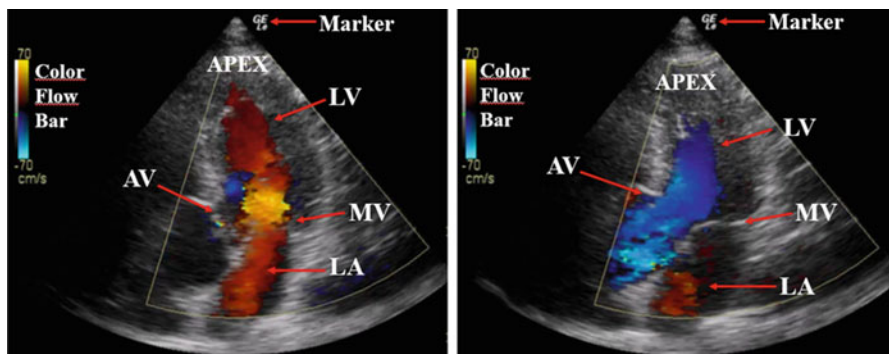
Apical 5 chamber view of the heart with color Doppler showing image orientation marker, apex of the heart, left ventricle (LV), mitral valve (MV), left atrium (LA), and aortic valve (AV). Left panel: image during diastole. Right panel: image during systole
